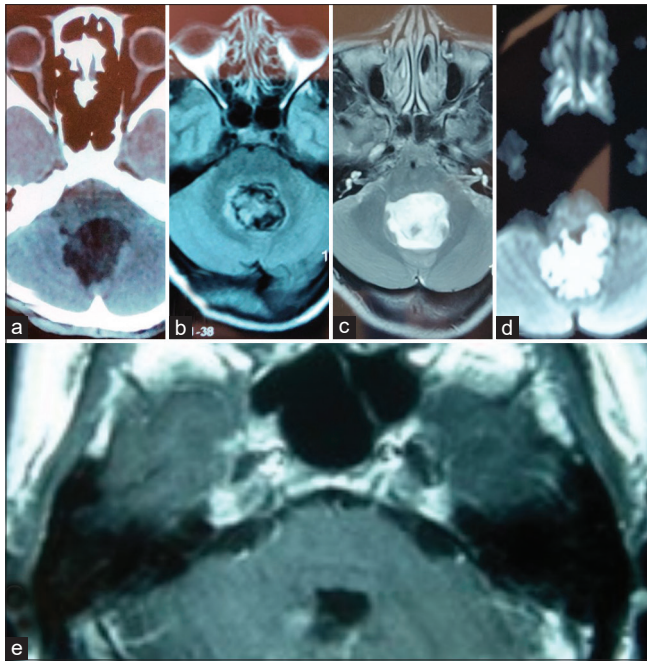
(a) Computed tomography head suggestive of hypodense lesion located in the fourth ventricle with expansion of the fourth ventricle. (b) On T1 axial magnetic resonance imaging, lesion in the fourth ventricle is hypo- to hyperintense. (c) On T2 axial magnetic resonance imaging, lesion in the fourth ventricle is hypo to hyperintense. (d) On magnetic resonance imaging, diffusion restriction was found. (e) Noncontrast computed tomography head showing complete excision of the lesion
